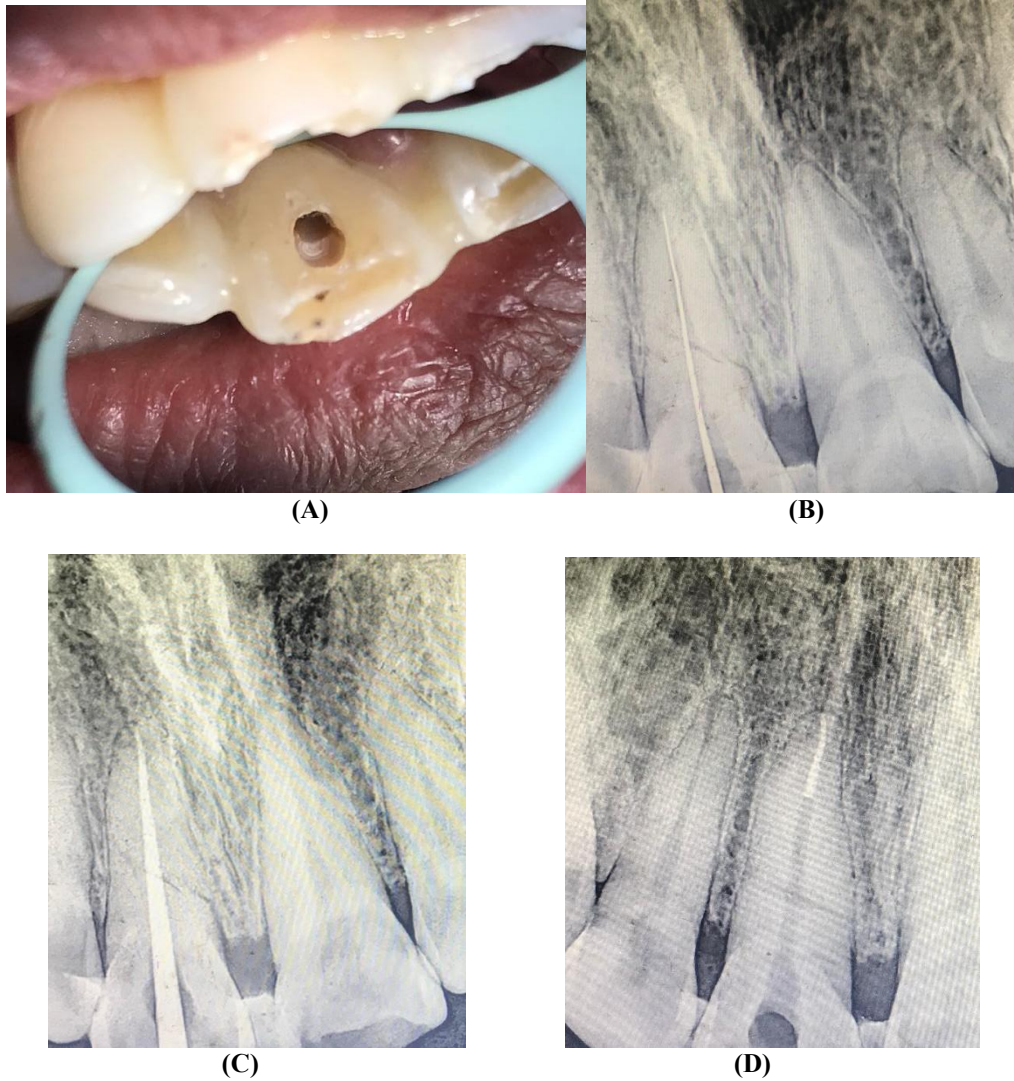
(A) Access opening of the tooth 11; (B) Radiograph showing working length determination; (C) Radiograph showing master cone fit check; (D) Radiograph showing sectional obturation
